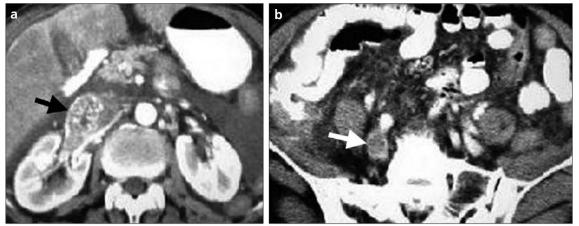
a, b. Contrast-enhanced CT images in the arterial phase (a, b) demonstrate the extension of the mass into the right renal vein (arrow, a) and right iliac vein (arrow, b).
